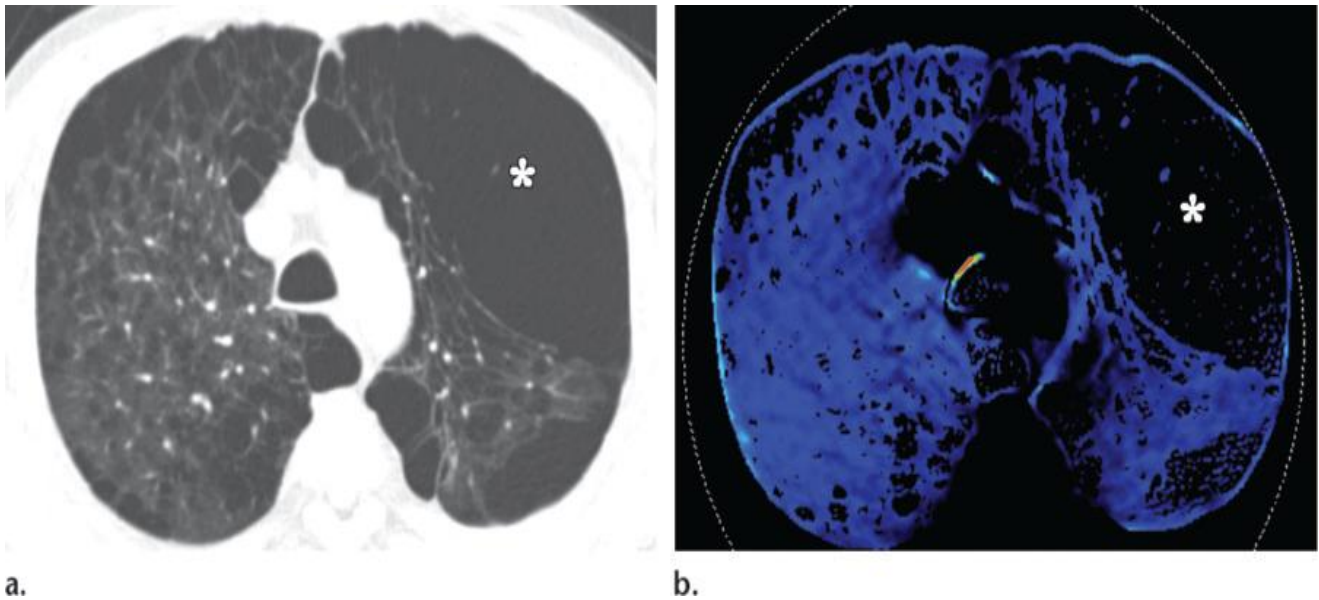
(a) CT (lung window) shows severe bullous emphysema especially in the left upper lobe (*) (b) Image from xenon ventilation CT shows a ventilation defect in the area of emphysema (*)[13]
